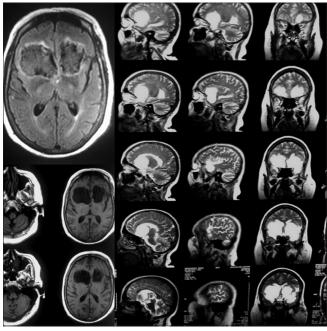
Magnetic resonance imaging of the patient with bifrontal epidermoid cyst; in T1 view two discrete, well-defined hypo-signal intraparenchymal mass in middle gyrus of both frontal lobe, lateral to falxcerebri is seen. The same hyper signal mass is detected in T2 view. Slight marginal edema can also be viewed
